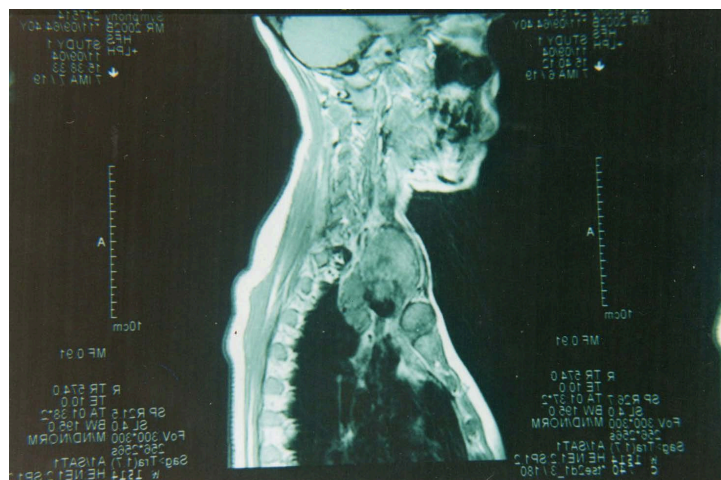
Sagittal MRI scan of neck showing superior mediastinal nodal involvement by papillary carcinoma of thyroid.
